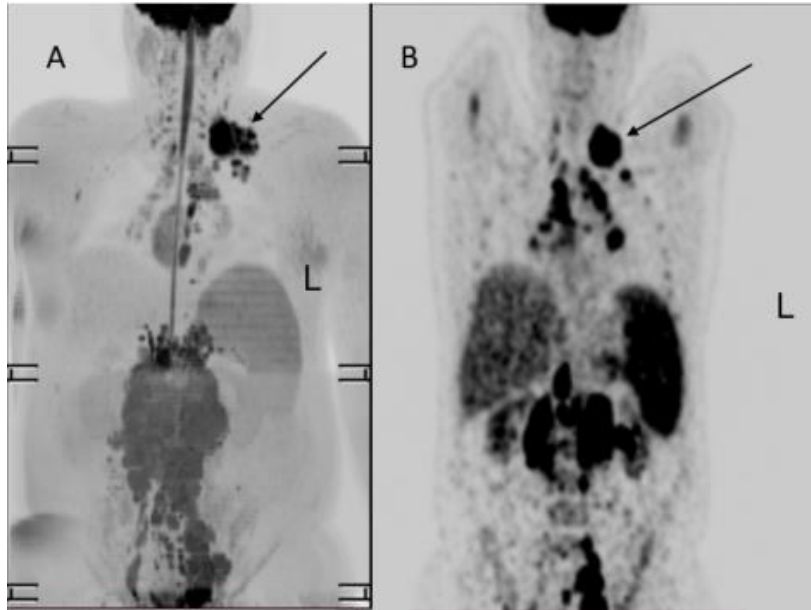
37 years old male, a case of Non-Hodgkin lymphoma, image A: left supraclavicular DWIBS lymphoma, image B: PET scan ( $^{18}\text{F}$ -FDG) hypermetabolic left cervical supraclavicular lymphoma (black arrow)
